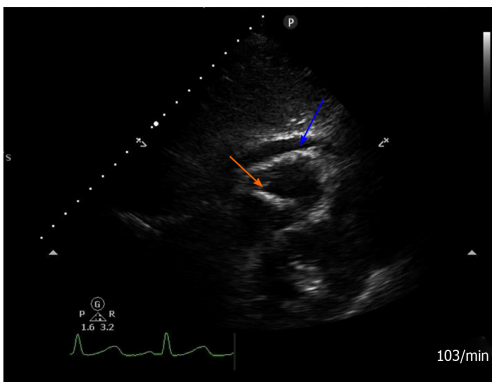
Postoperative transthoracic echocardiography view. Subxiphoid four chamber view modified for the right ventricle showing a hyperechogenic linear-shaped image attached to the apical portion of the right ventricle (orange arrow), and pericardial effusion (blue arrow).
